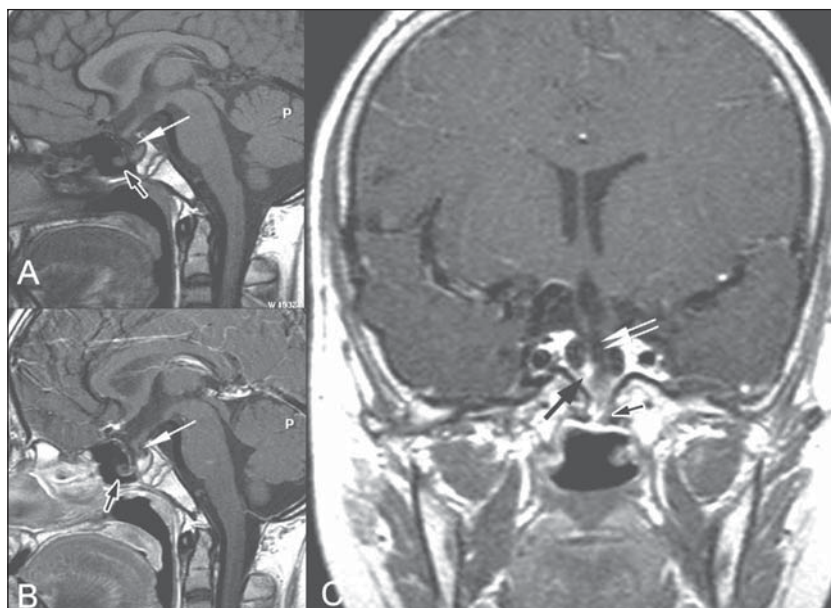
MRI images of the sagittal plane on T1 without iodine contrast (A), sagittal with iodine contrast (B) and coronal with iodine contrast (C) showing the hypophysis in the inner sella (black arrow). Inferior retraction of the pituitary stalk (white arrow), the optic chiasm and anterior portion of the third ventricle to the inner sella (double white cross). The bone flaw on the sellar floor with the hernial content of undistinguished anatomic aspect, characterized as gliocèle (black arrow with white border), is located into the sphenoidal sinus.
